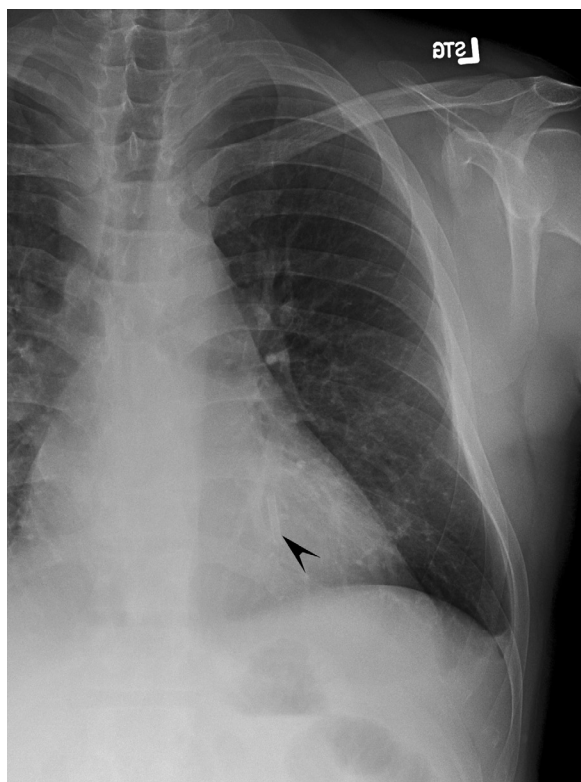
■ Anteroposterior (AP) supine chest x-ray. Catheter fragment (*arrow*) in a left lower lobe pulmonary artery branch.
